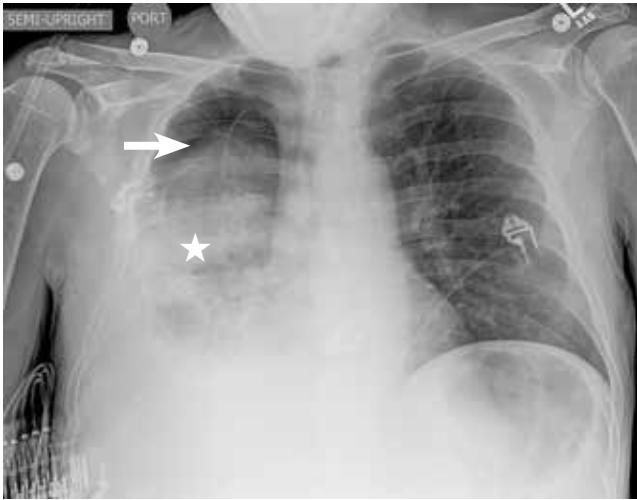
Radiography after high-volume thoracentesis showed pneumothorax (arrow).
